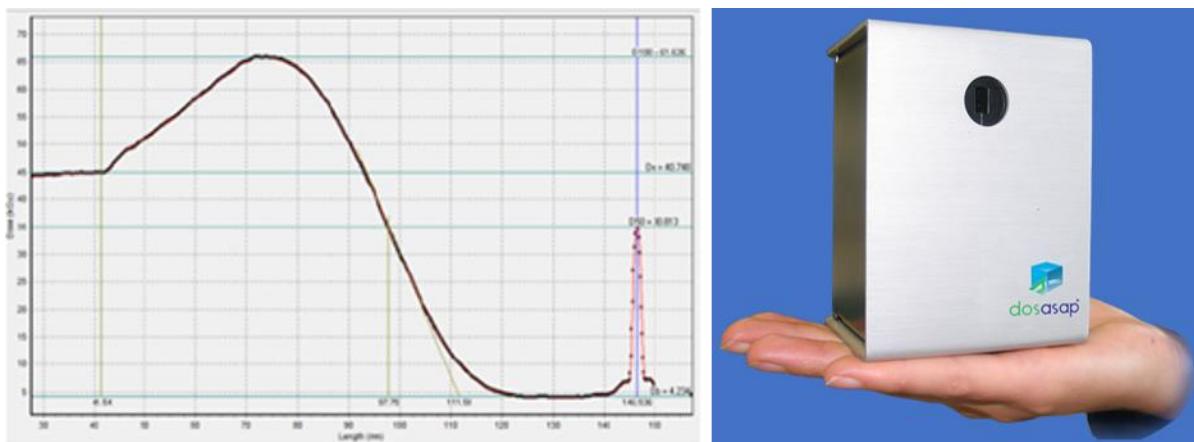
Example of an electron beam depth-dose curve measured using CTA dosimeter film placed in an aluminium wedge (left), by the Aerial dosasap® scanner (right).
